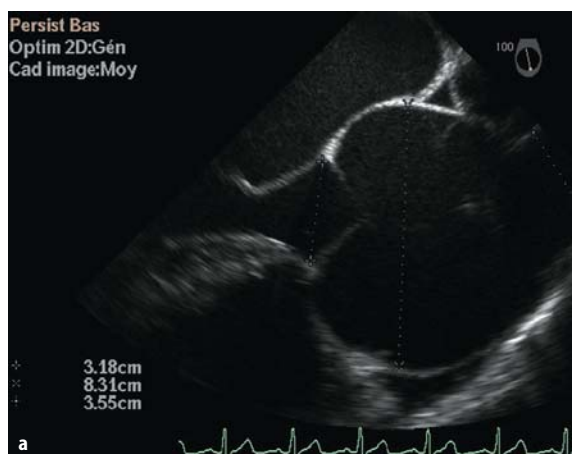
Marfan syndrome: multiplane transesophageal views. a Enlargement of aortic annulus and sinus of Valsalva. b Color Doppler flow of aortic regurgitation. c Incomplete closure of aortic valves with central regurgitation
